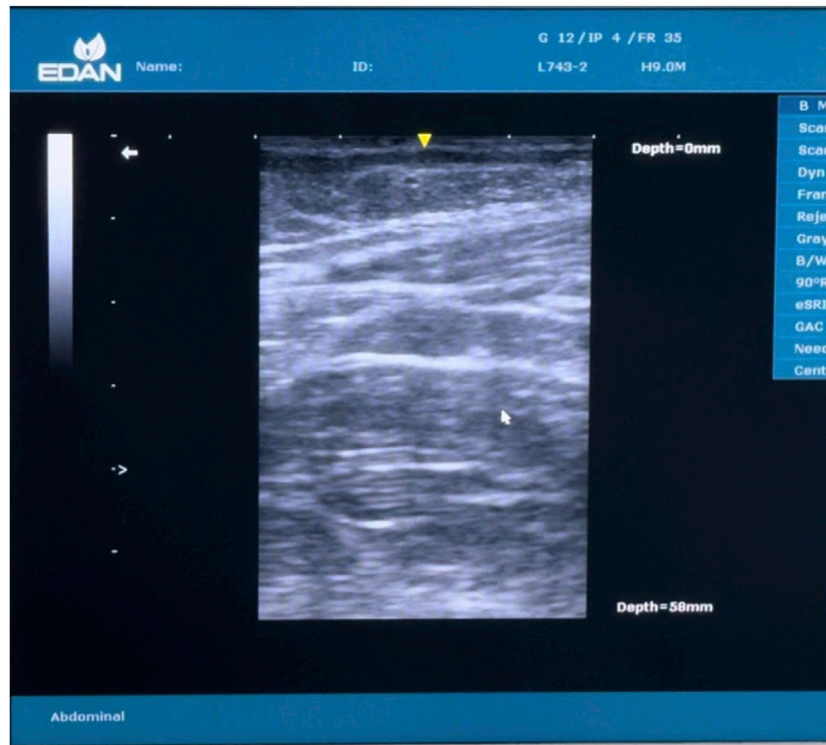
Ultrasound image showing 3 layers.
